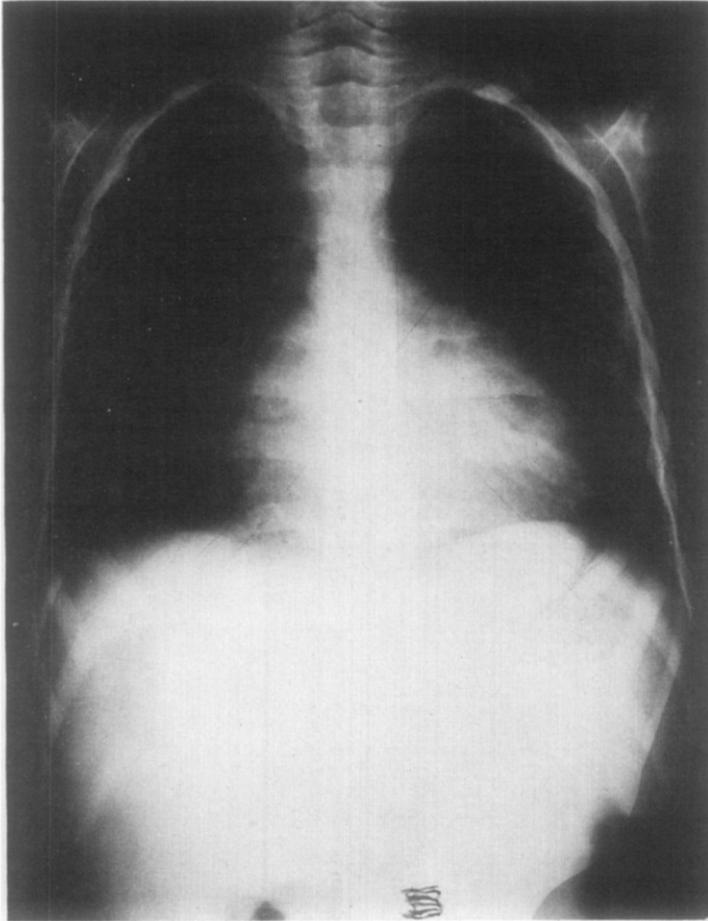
An ordinary x-ray film of a 4-year-old child with tricuspid atresia and cor triloculare with persistence of the truncus arteriosus.
